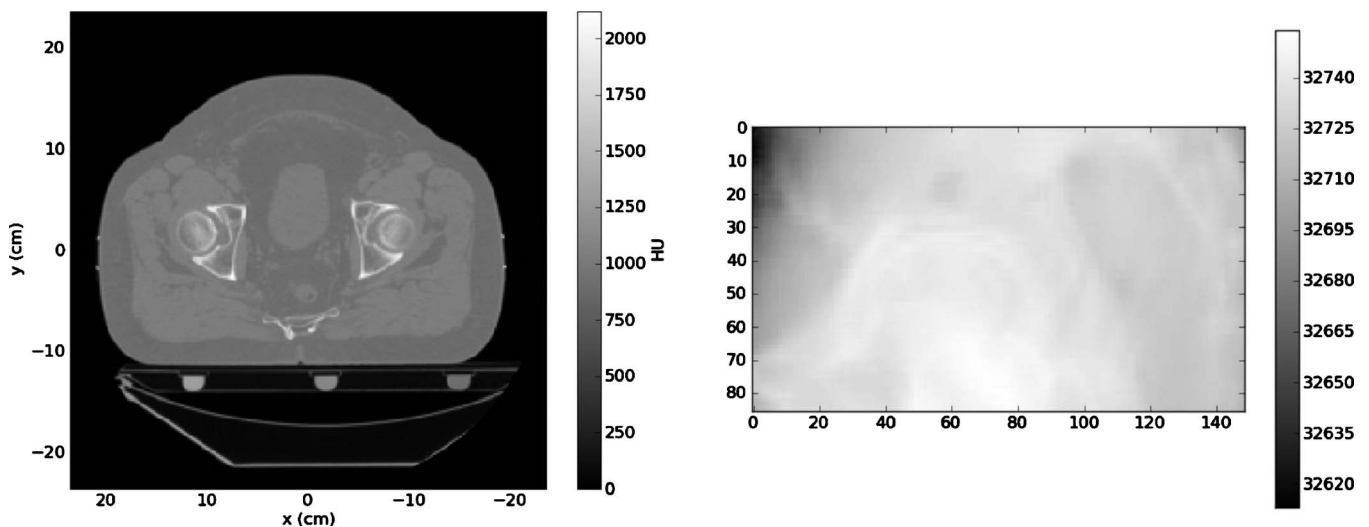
A slice through the pelvic CT image (left) and a projection through the CT image (right).
